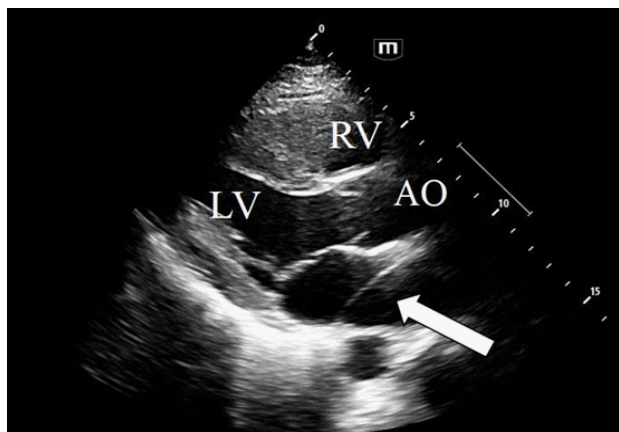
Parasternal long axis view showing a flap crossing the left atrial chamber (white arrow). LV, left ventricle, RV, right ventricle, AO, aorta.
